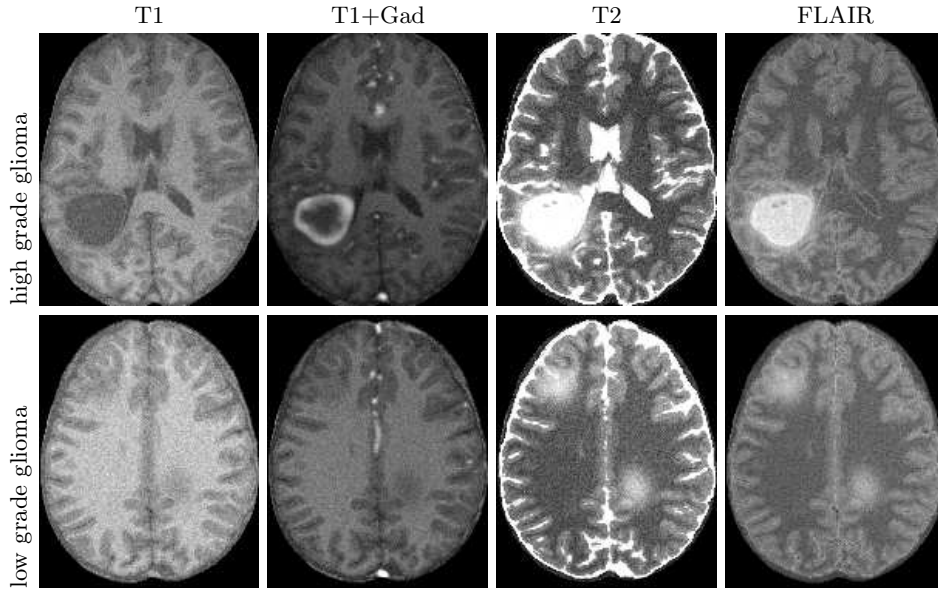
Synthetic MR images. From left to right: T1, T1+Gad, T2, and FLAIR MR images. Top row: bulky tumor characterized by a large necrotic and a surrounding vascularization pattern. Bottom row: very infiltrating tumor characterized by the extended of the edema.
